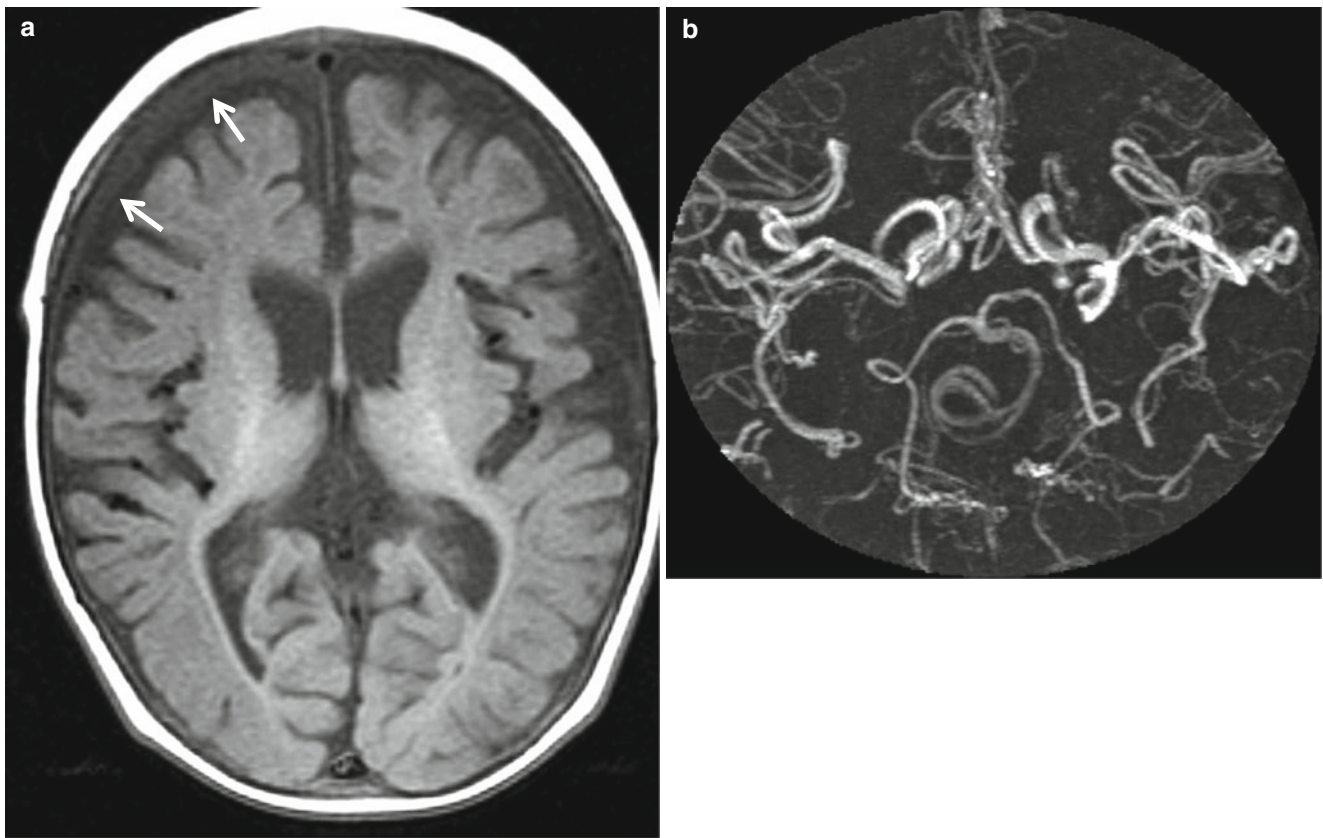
Bilateral SDH in an infant with Menke's kinky hair disease. (a) T1-weighted image shows right SDH (*arrows*). In addition, the brain appears mildly atrophic, and prominent signal void vessels are seen. (b) MR angiography shows tortuous cerebral vessels
